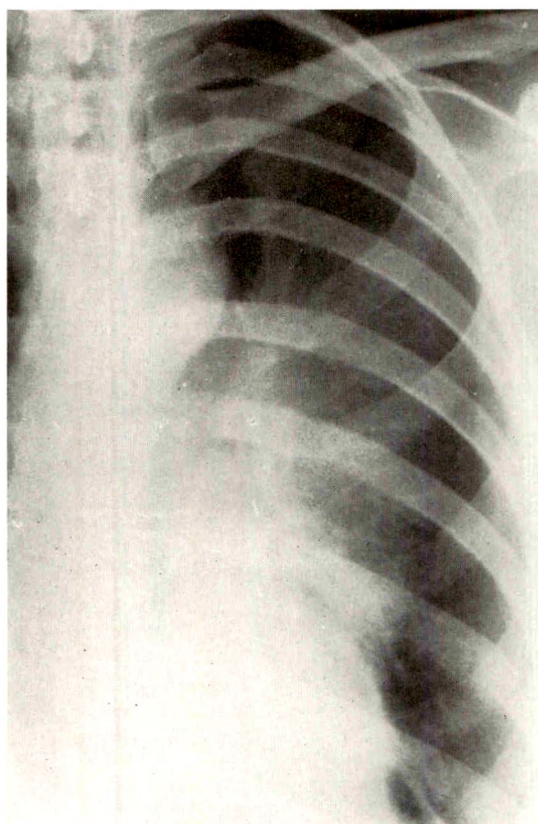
Case III. Posteroanterior chest roentgenogram (Sept. 3, 1963) shows the right side to be normal. Trachea is midline. Left hilus is in normal position. There is reduction of vascular markings in the left lower lung field mainly. Major vessels are spread out. The anterior segment of the left upper lobe is displaced downwards. A paravertebral density (arrows) is seen behind the heart.
